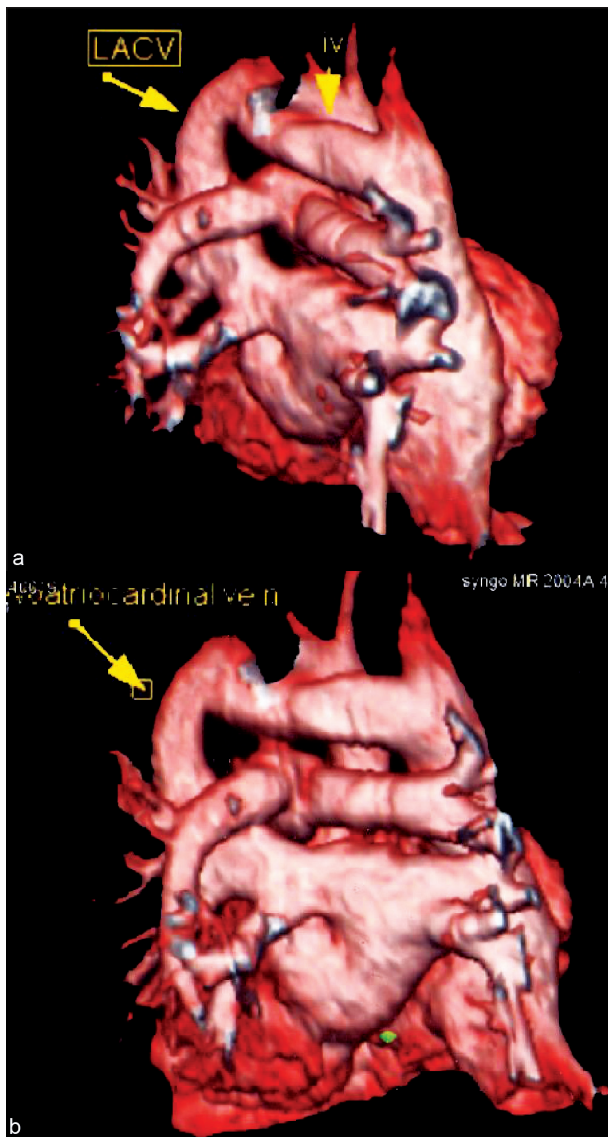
Cardiac magnetic resonance imaging shows normal return of pulmonary venous system and connection between LACV and left atrium in posterior views
